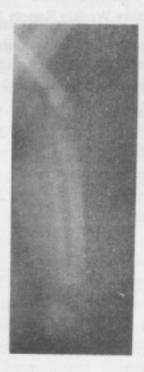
X-ray of neighborhood child showing white line.
